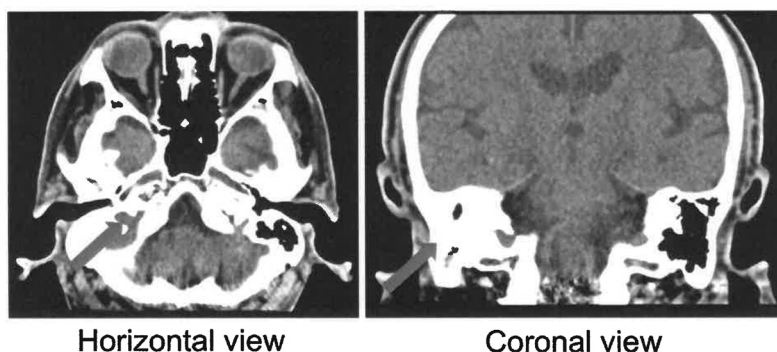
Head CT performed on admission shows poor pneumatization of the right mastoid cells and a shadow in the soft tissue from the right epitympanum to the middle ear.
